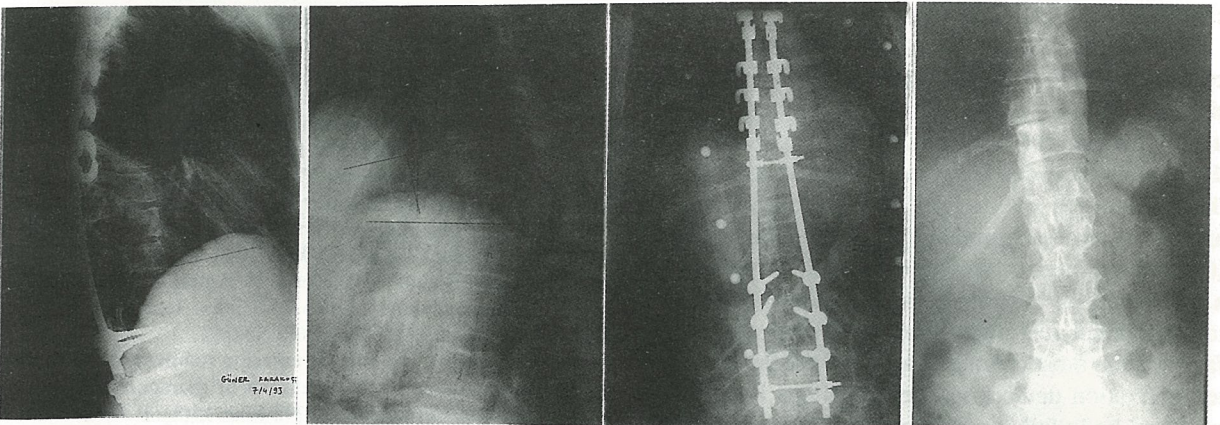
Preoperative and postoperative anteroposterior and lateral x-rays of a tumor patient.
